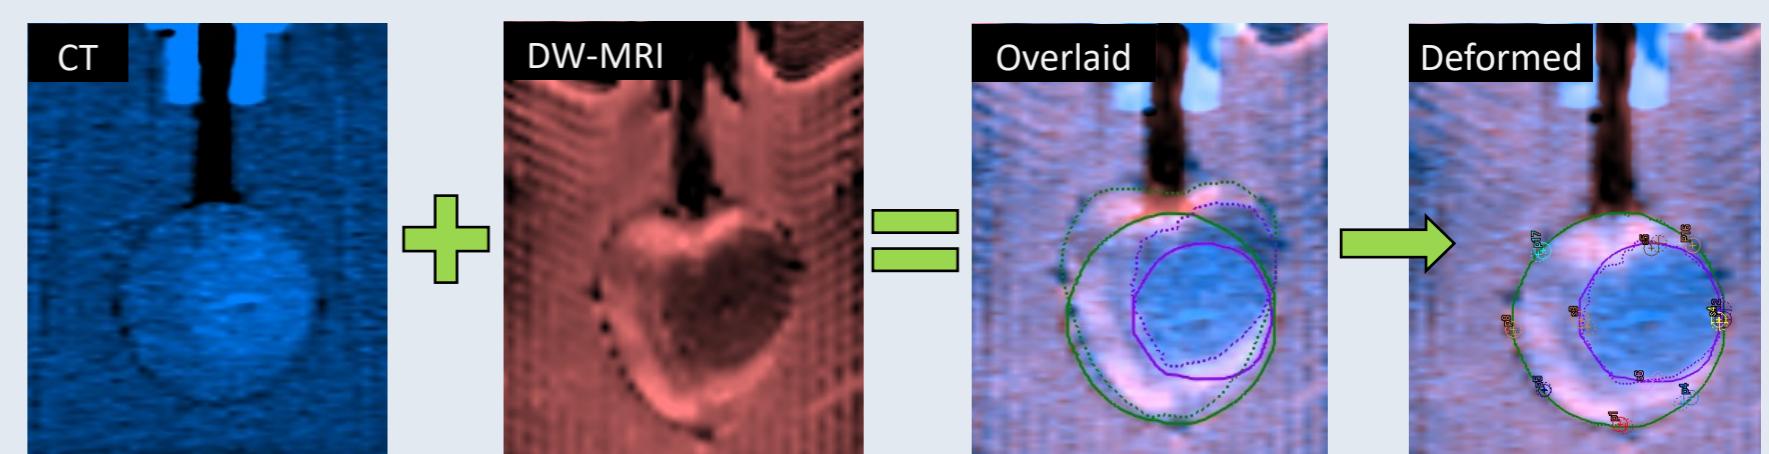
Image with CT and DW-MRI, and quantify effects of image distortion
